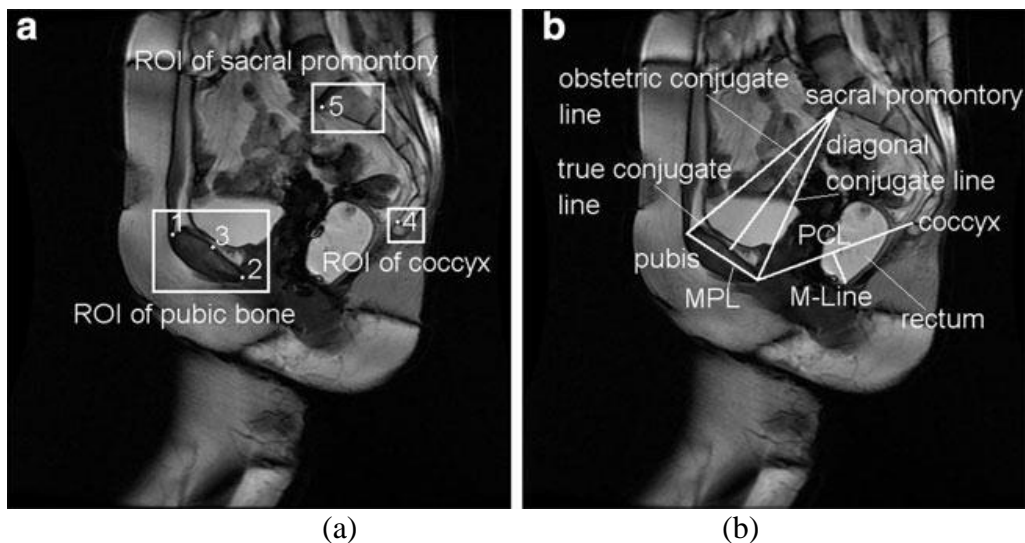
Point of interests and proposed MRI-based features. (a) Point of interest, (b) Current and proposed MRI-based features
